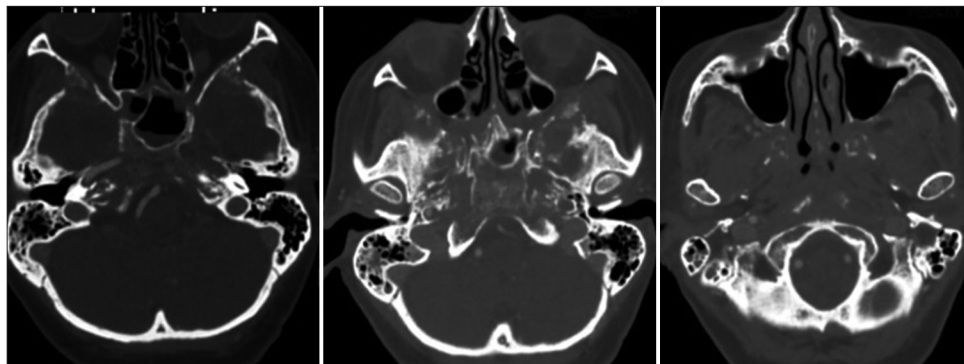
Axial computed tomography scan, bone window with osteomyelitis extension within the occipital bone base and the sphenoidal sinus.
